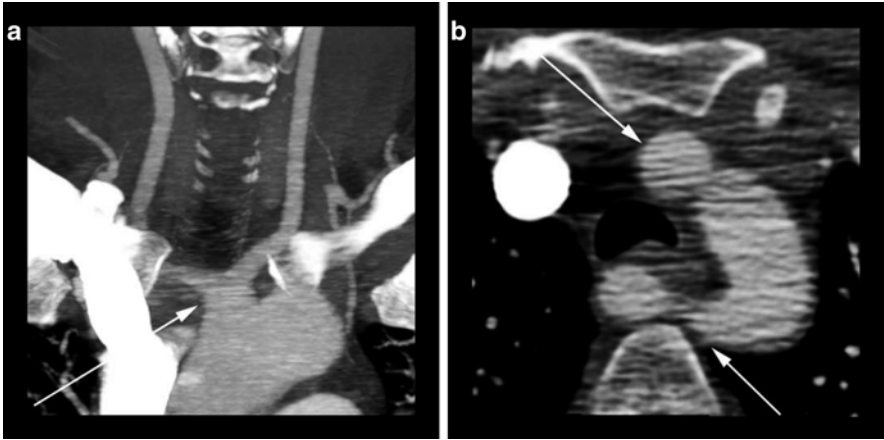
64-year-old female presenting for acute stroke evaluation. (a) A coronal CTA MIP image displays a common origin (*arrow*) of the bilateral common carotid arteries in the setting of an aberrant right subclavian artery. (b) A standard axial CTA image reveals the common origin of the carotid arteries (*top arrow*) as well as the aberrant right subclavian artery (*bottom arrow*) coursing behind the esophagus and trachea
